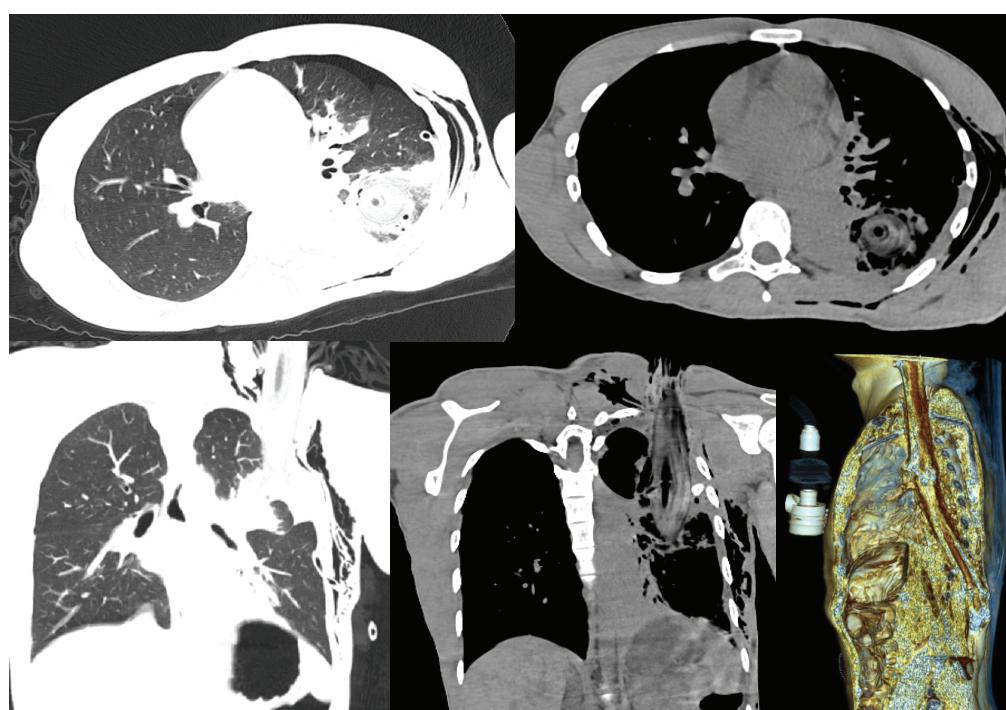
Emergency CT scan performed after admission
